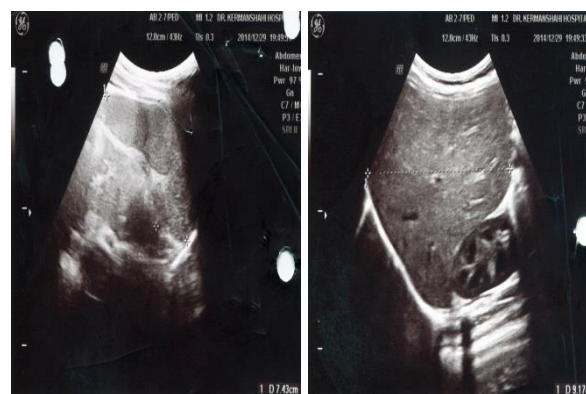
Ultrasound images of kidney
